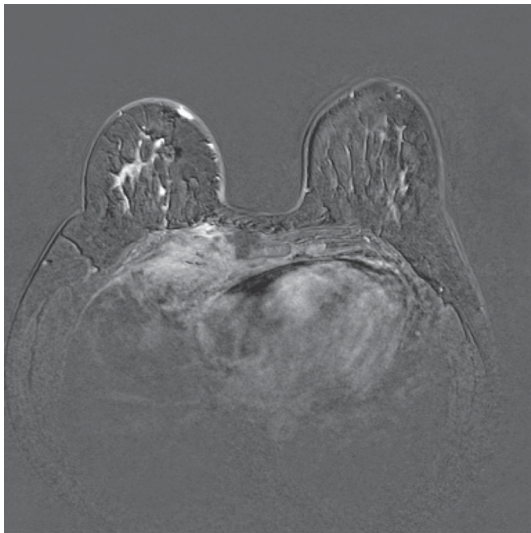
Breast MRI, T1 with IV contrast and subtracted axial image, showing irregular shape chest wall mass in medial deep part of right side of chest wall with involvement of ribs and pleura and extension to the mediastinum
